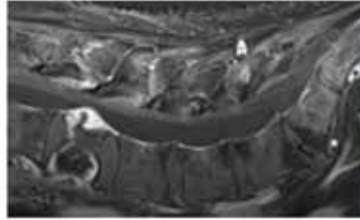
MRI lumbar spine, T1 Dixon sagittal sequence, showing progression of L2 osseous metastasis in 2023
